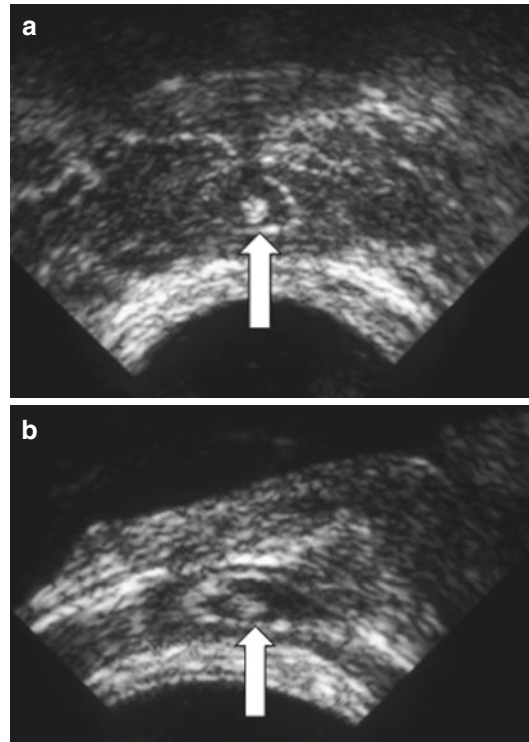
Stone in dilated ejaculatory duct: transverse (a) and longitudinal (b) transrectal sonograms show a very small hyperechogenic stone (arrows) in the dilated right ejaculatory duct
